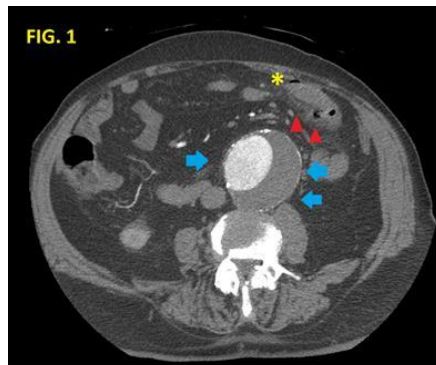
CT axial images show jejunal diverticulitis (red arrowhead) and extraluminal air bubbles (yellow *). Also big abdominal aneurysm with a non-complicated mural thrombus is present. (Blue arrows).
